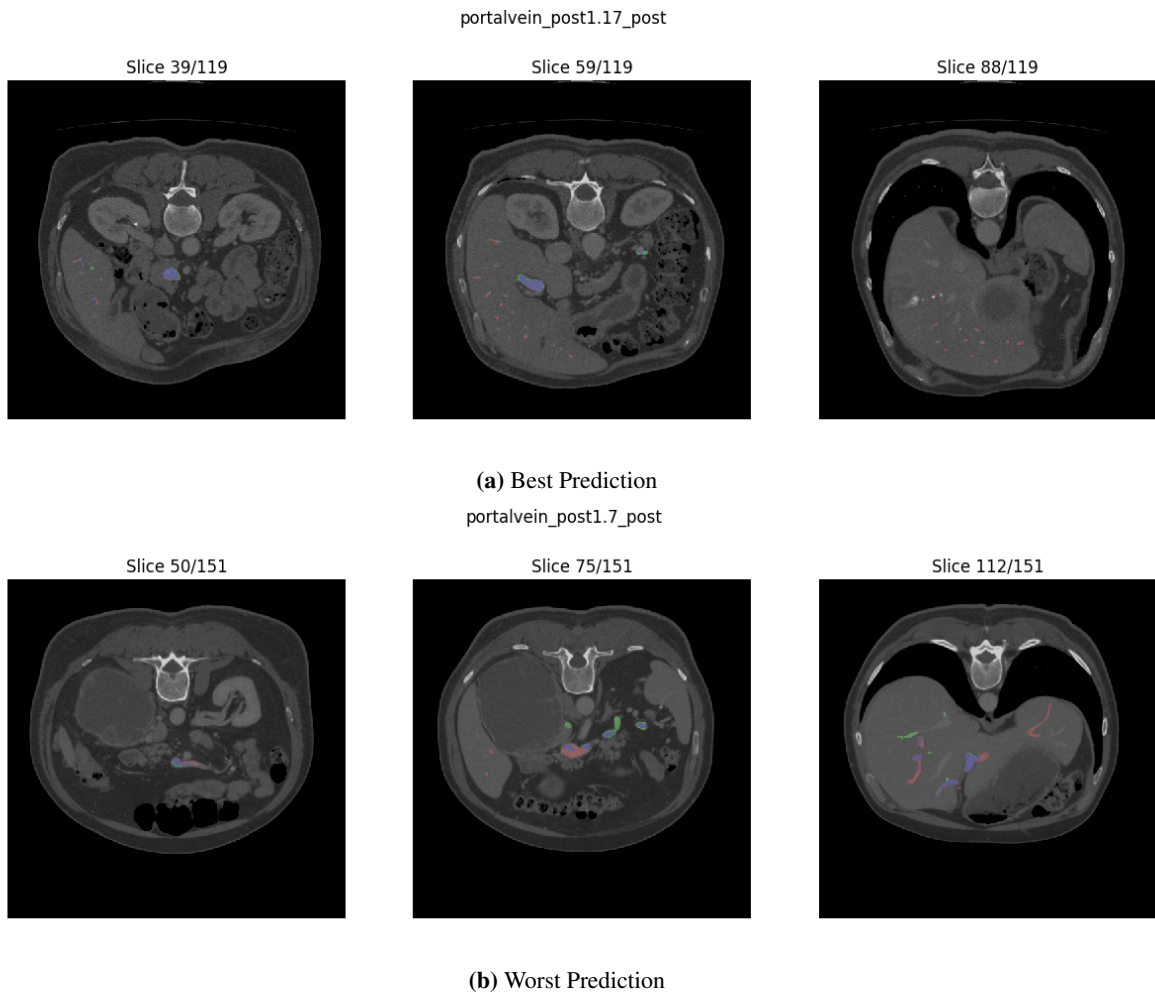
A selection of some of the CT slices of the BVNet3D model's best and worst prediction of the portal vein splits, where the corresponding prediction is overlaid. The prediction is color-coded with blue=TP, green=FP, and red with low opacity=FN
